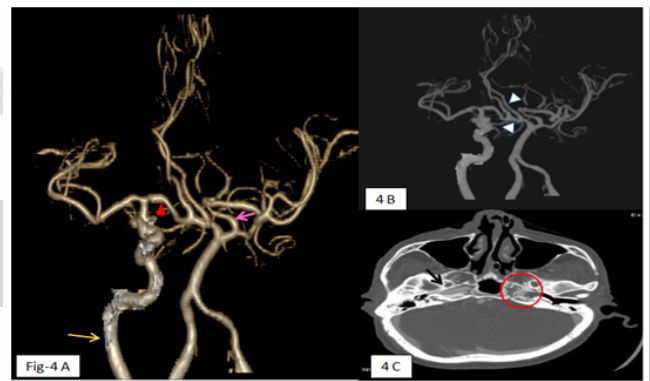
A and Fig-4 B, 3D cerebral CTA images show agenesis of the left internal carotid artery (ICA) whereas the right ICA is normal (yellow arrow). The collateral circulation is well established. The left middle cerebral artery is supplied by the posterior communicating artery (pink arrow), and the left anterior cerebral artery is supplied by the anterior communicating artery (white arrowheads). The left A1 segment (the first segment of the anterior cerebral artery) is absent. The right A1 segment is normal (red arrowhead). 4C, Axial CT bone window of the same patient showing an absent bony carotid canal (red circle) on the left side. The normal carotid canal on the right side is marked with a black arrow for comparison.
